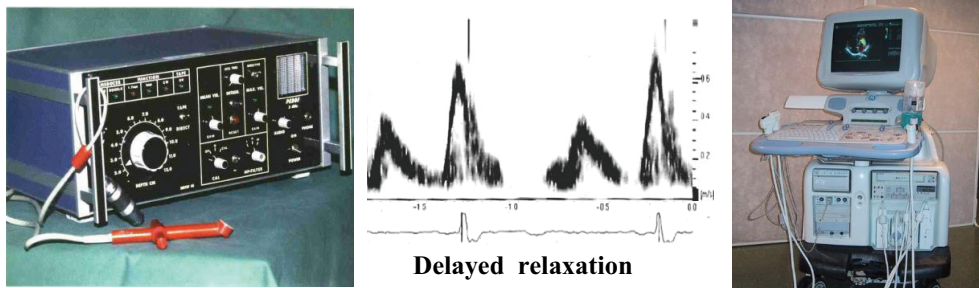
Left: PEDOF (Pulsed and continuous wave Doppler (1976), Middle: Mitral inflow by PEDOF showing delayed relaxation and Right: GE Vivid 7 scanner from 2000 (the scanner used for the echocardiographic examinations to which this thesis is based). Pictures applied from Hans Torp.
